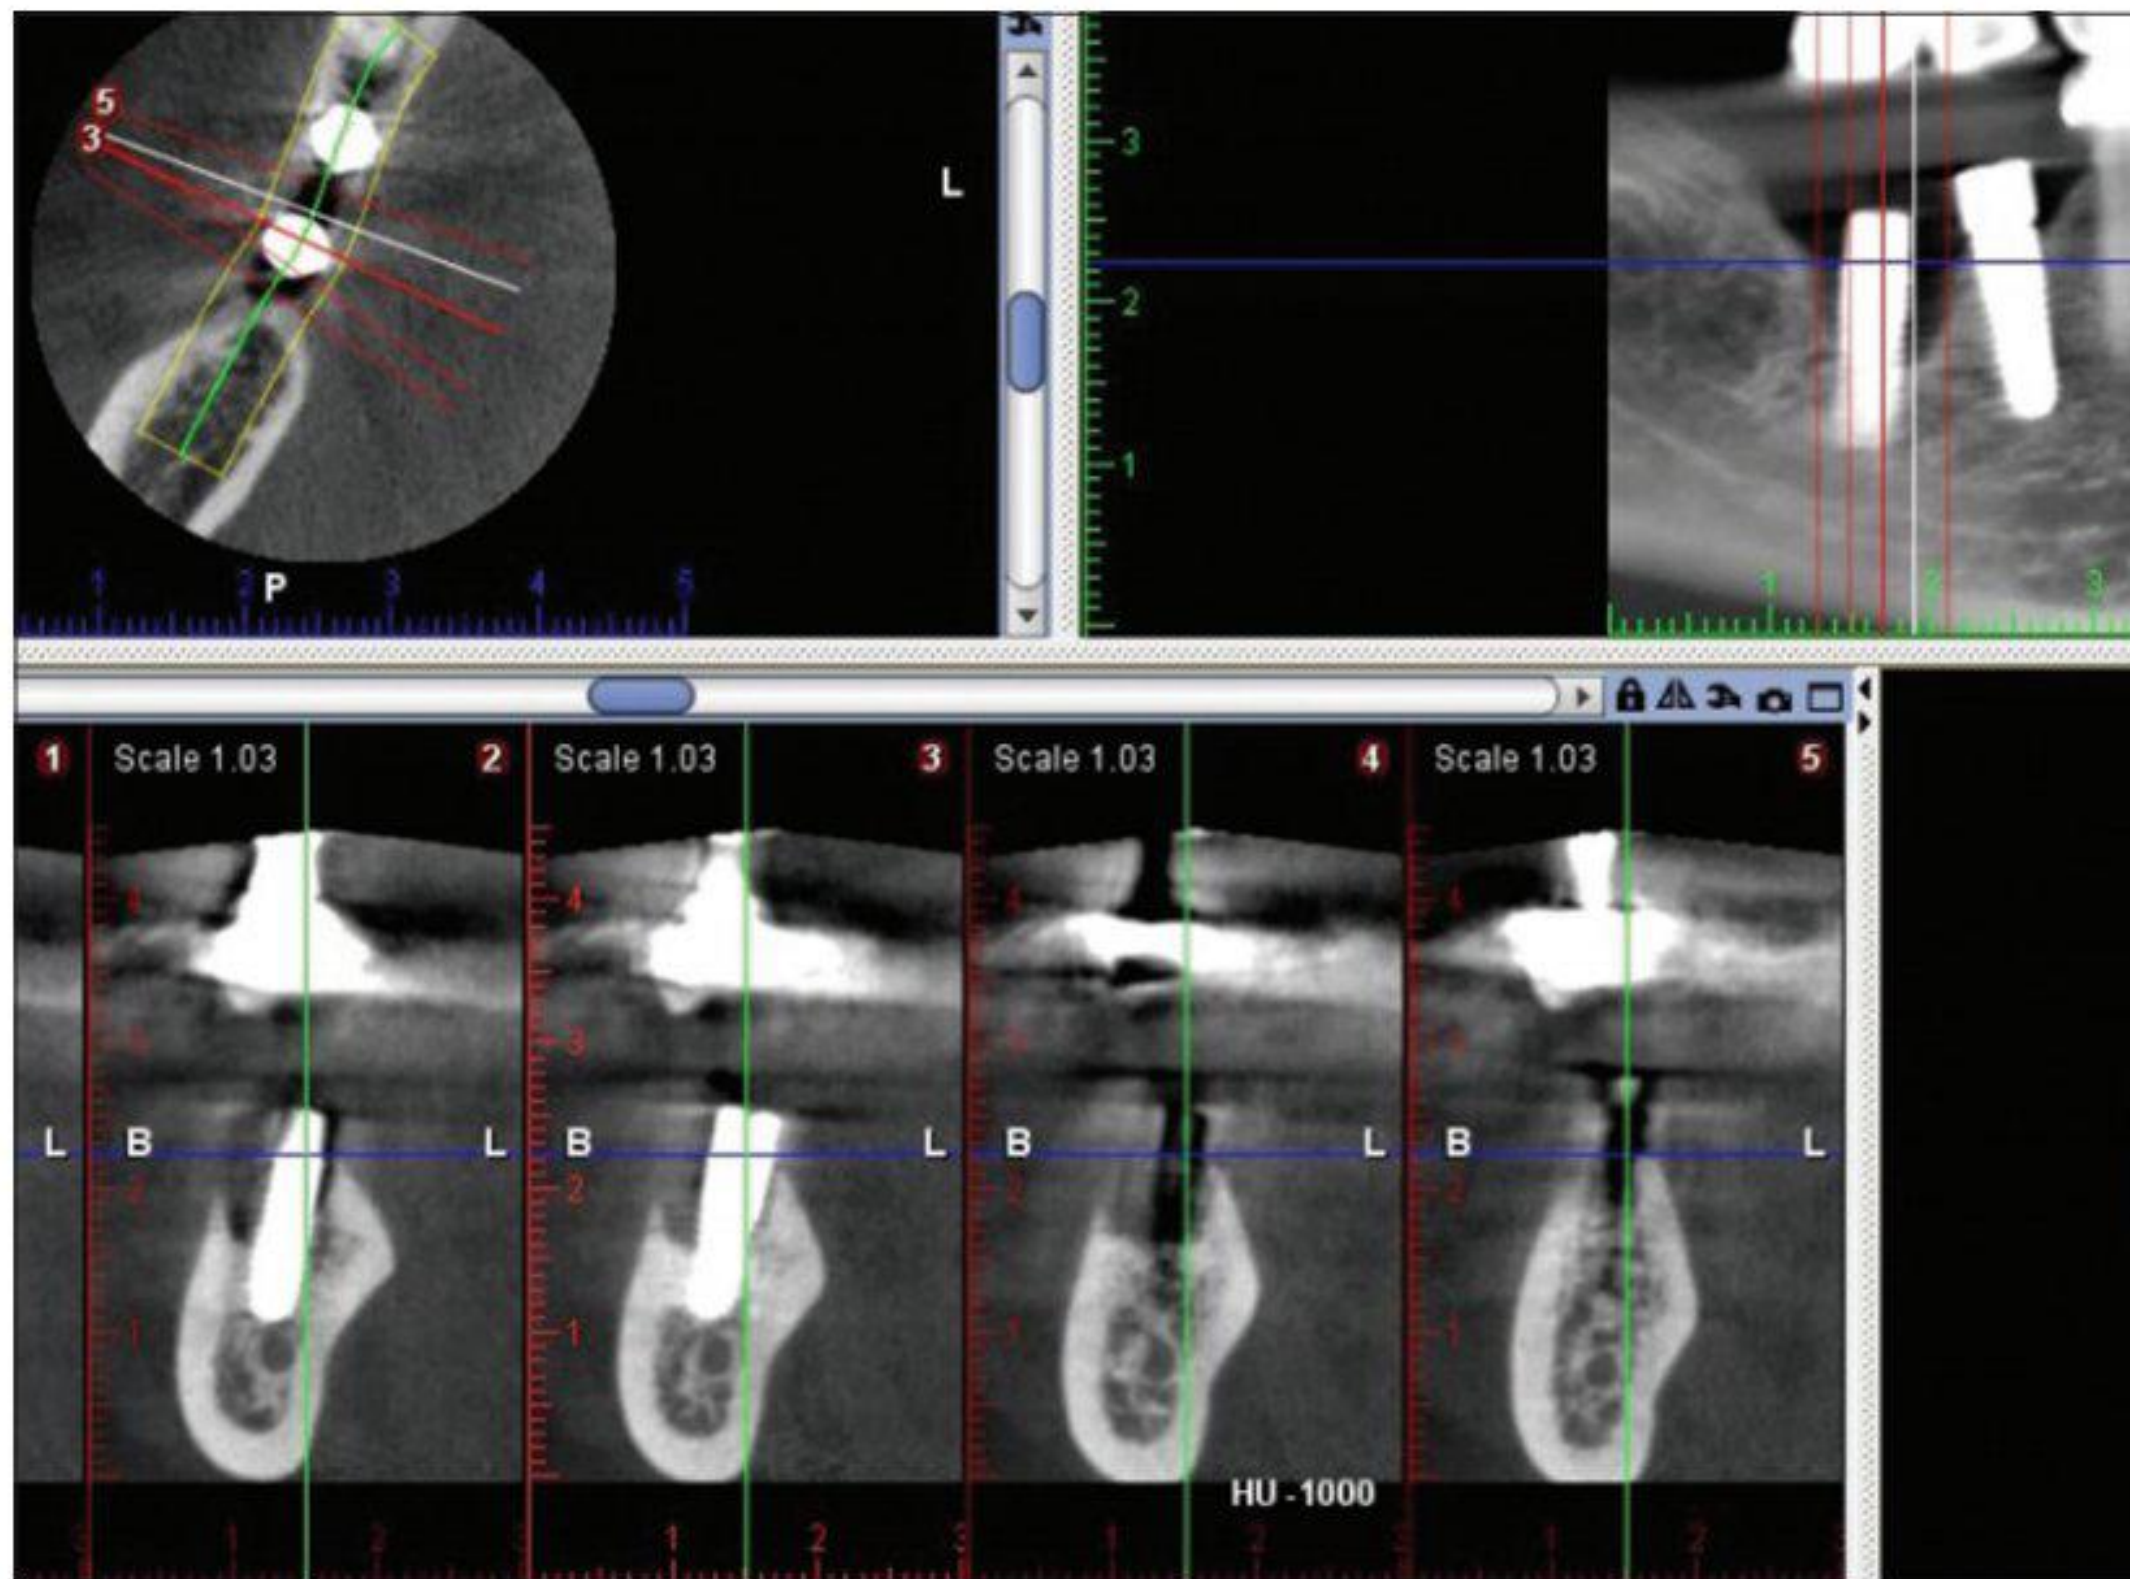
Preoperative cone-beam computed tomography
